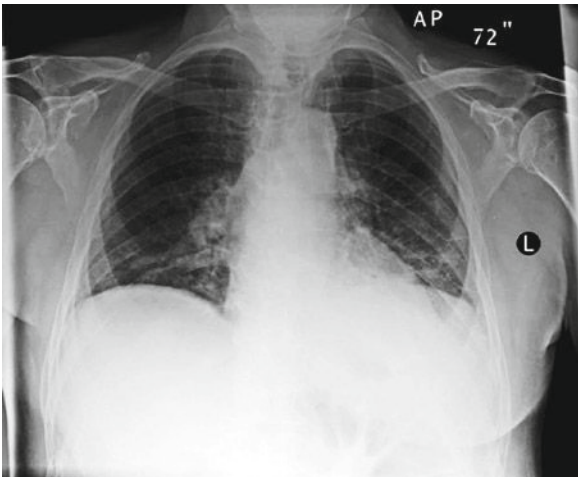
Chest X-ray of a patient with chronic lymphocytic leukemia and CMV pneumonia showing interstitial opacities in both bases
